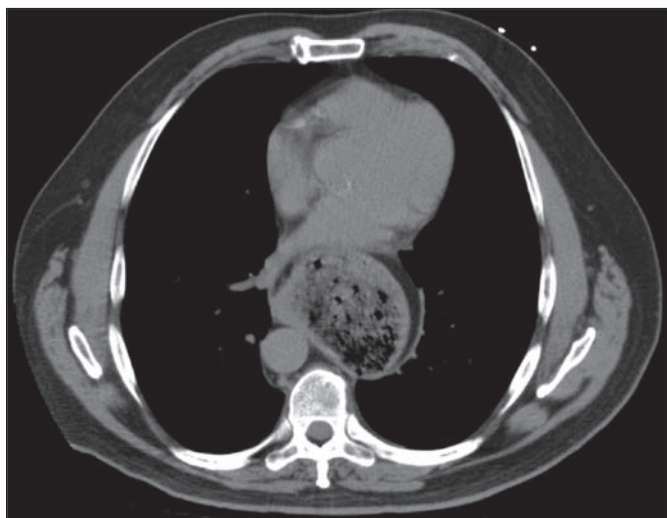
CT of the chest demonstrating an intrathoracic stomach due to a large hiatal hernia.
